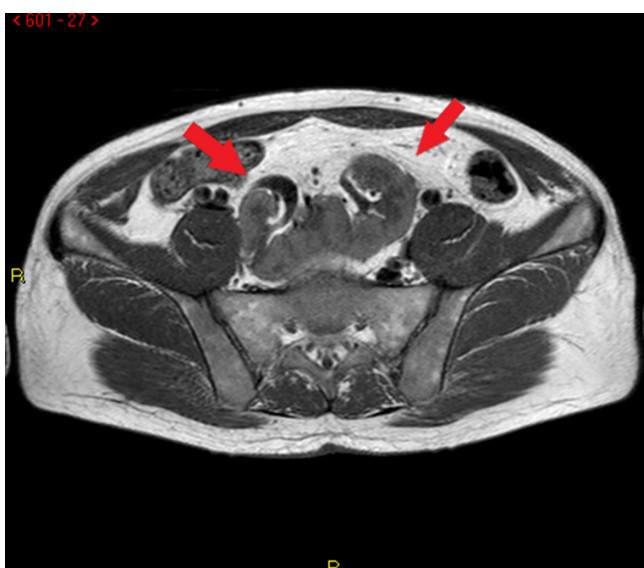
MRI (TSE T_2 -weighted): pelvic location of pancake kidney in coronal view (arrows). TSE, turbo spin echo.
